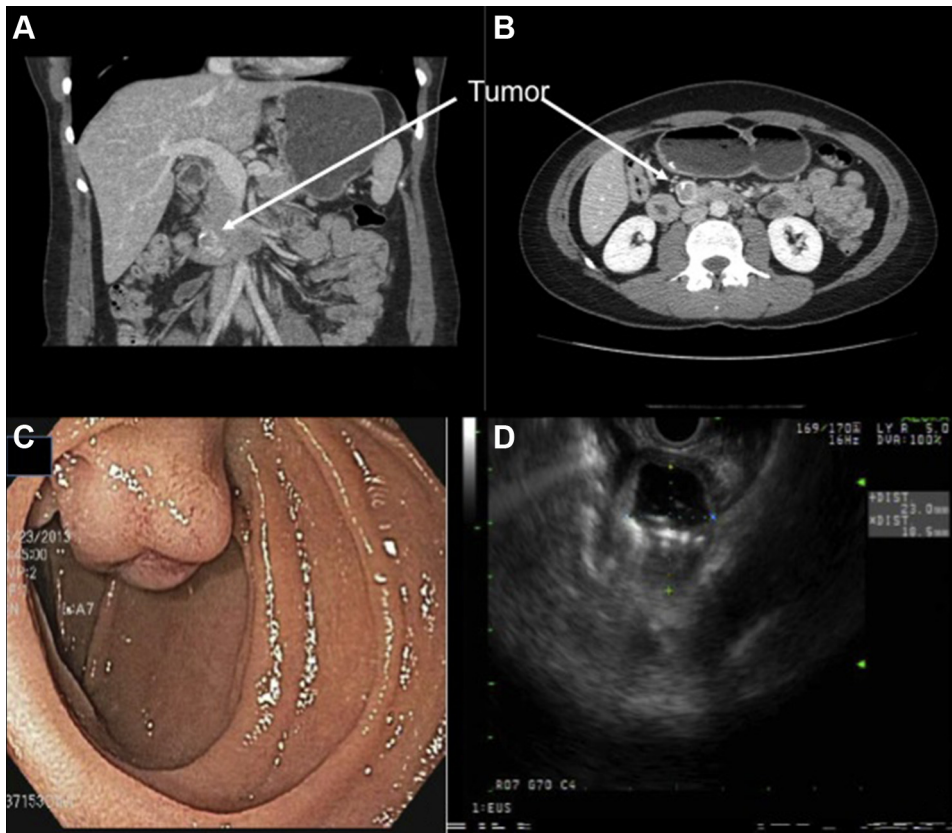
Appearance of duodenal GIST on CT imaging (A and B), endoscopy (C), and endoscopic ultrasound (D).
